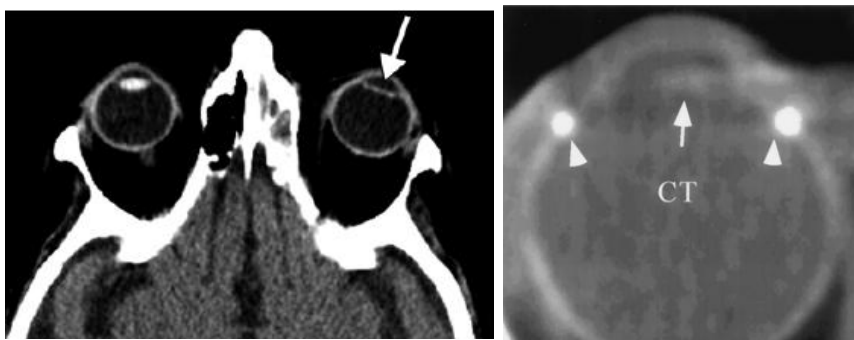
LEFT: Axial CT depicting posterior chamber artificial IOL (arrow) as a thin hyperattenuating linear structure. This may be compared to the other eye for which the native lens remains intact [1]. RIGHT: Axial CT depicting anterior chamber artificial IOL (arrow) and silicone band (arrowheads) [6].
